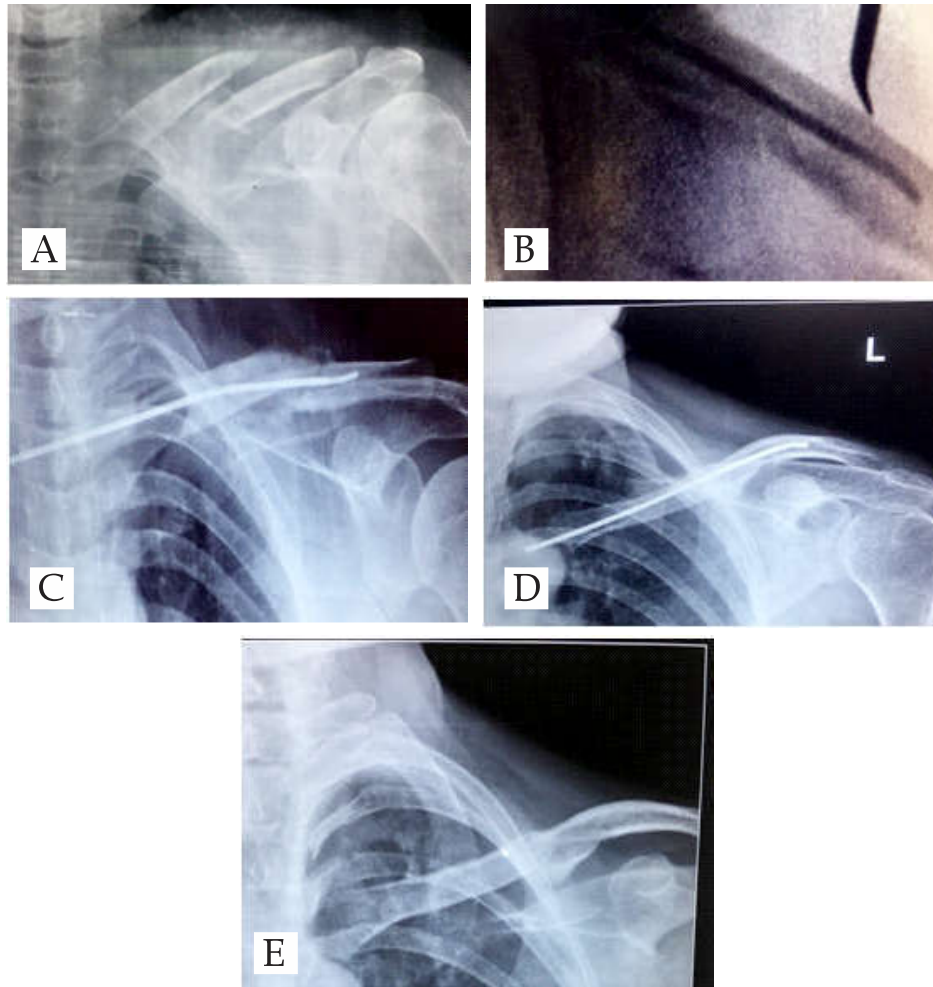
Case-2 radiographs- a.pre op, b. post op, c.6 week f/u, d.10 week f/u, e.union
